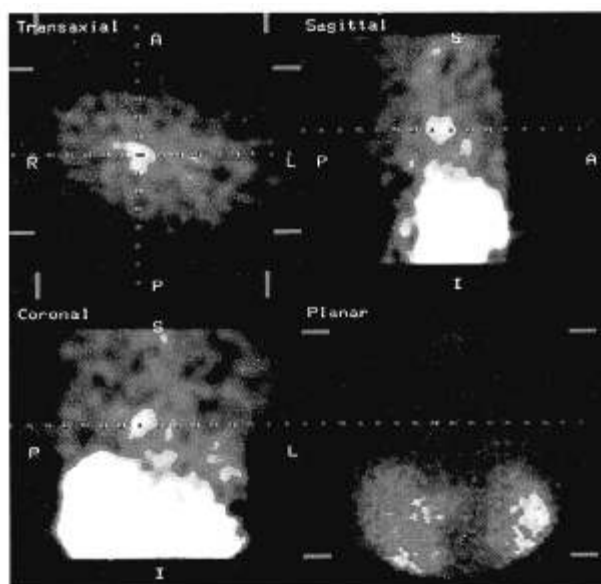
Single-photon emission computed tomography (SPECT) image of a patient with a bronchial carcinoid tumour not localized with planar imaging. The tumour was found to express high-affinity somatostatin receptors when evaluated following surgery.
